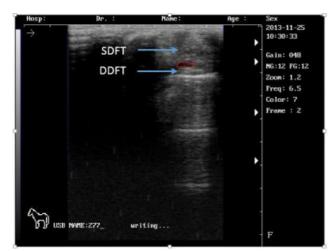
Cross section of tendons of bone marrow treated group at 30 days post operatively indicates mild fluid in the SDFT (Red), with slower to demonstrate evidence of healing on ultrasound.
